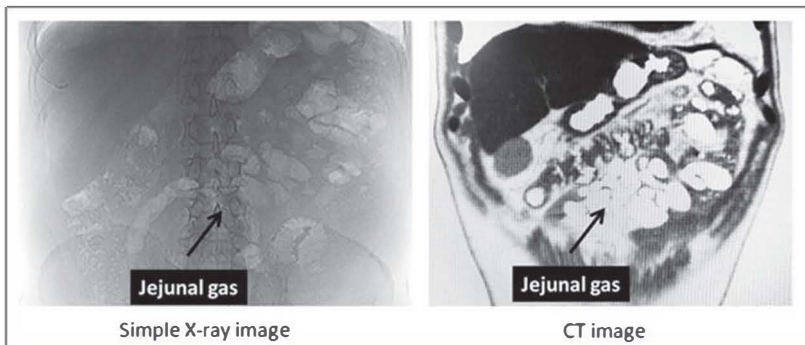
A CT is the most effective method to confirm the small intestine SIBO gas of SIBO.*
